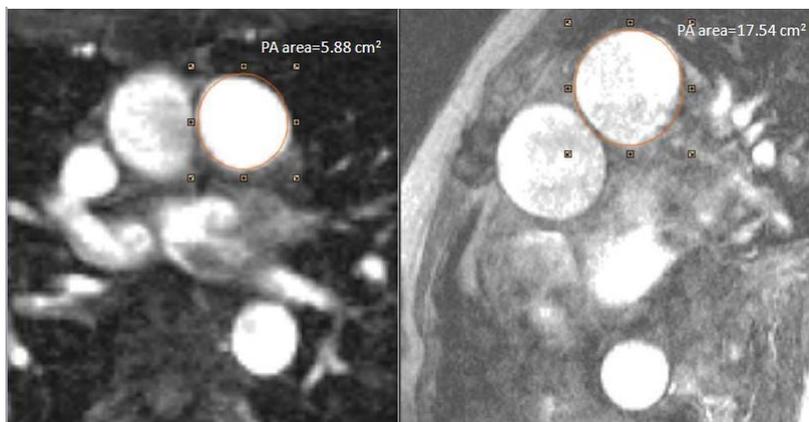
Demonstration of a phase contrast cardiac magnetic resonance image with MPA area measurement in healthy volunteer (left, max PA area = 5.88 cm²) and repaired TOF (right, max PA area = 17.54 cm²).
